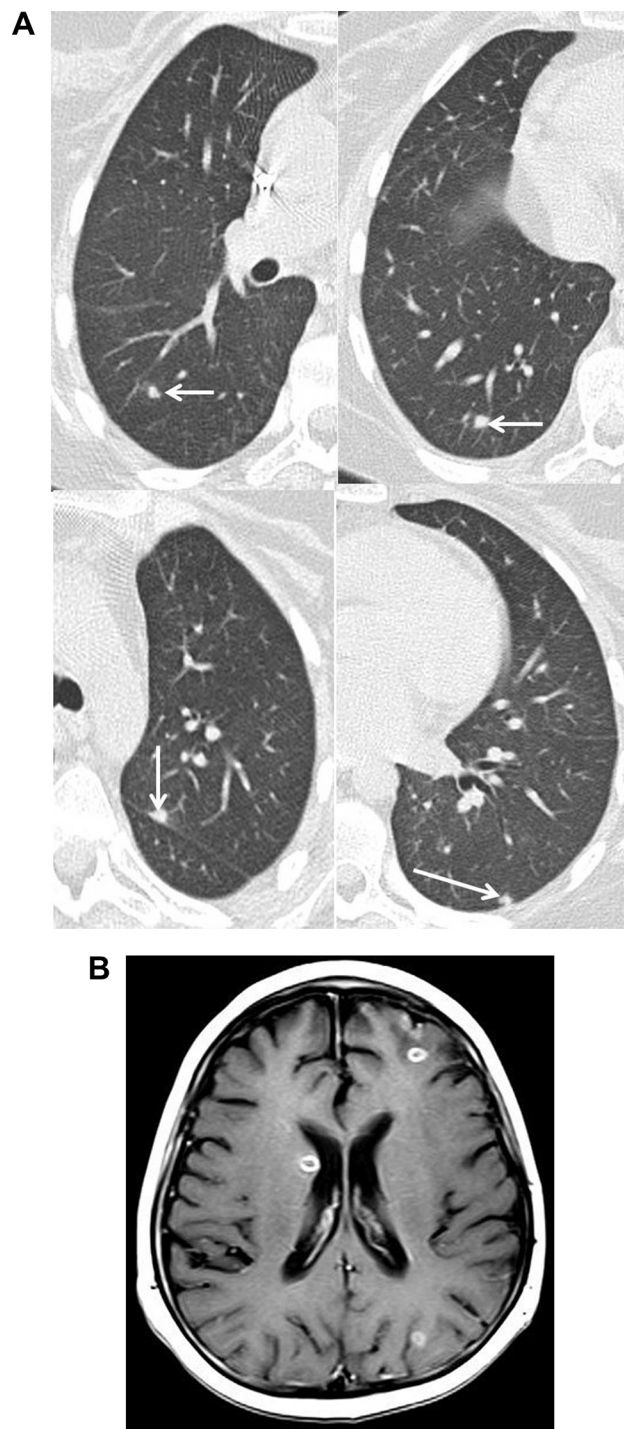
(A) Axial thorax CT image shows multiple subpleural and parenchymal millimetric nodules surrounded by mild ground-glass opacities (halo sign) in the upper and lower lobes of bilateral lungs (arrows). (B) Axial T1-weighted MR image of the brain obtained after the injection of contrast material shows multiple ring-enhancing lesions at the cortico-medullary junction in the hemisphere, consistent with the abscess. CT = computed tomography; MR = magnetic resonance.
